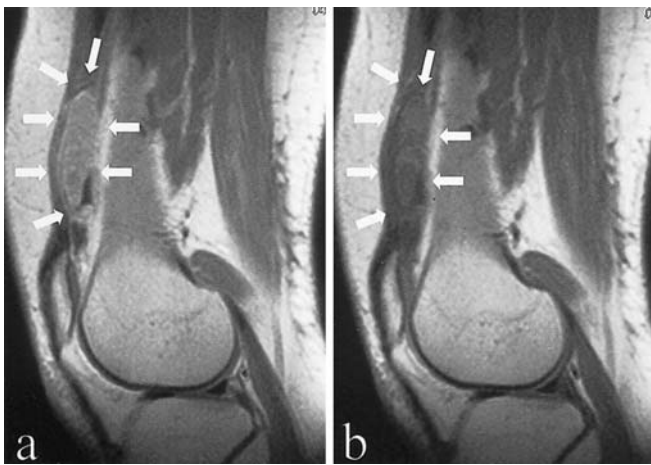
MRI of the right knee showing a mass with a relatively low signal intensity in the suprapatellar bursa in a T1-weighted and b T2-weighted images
